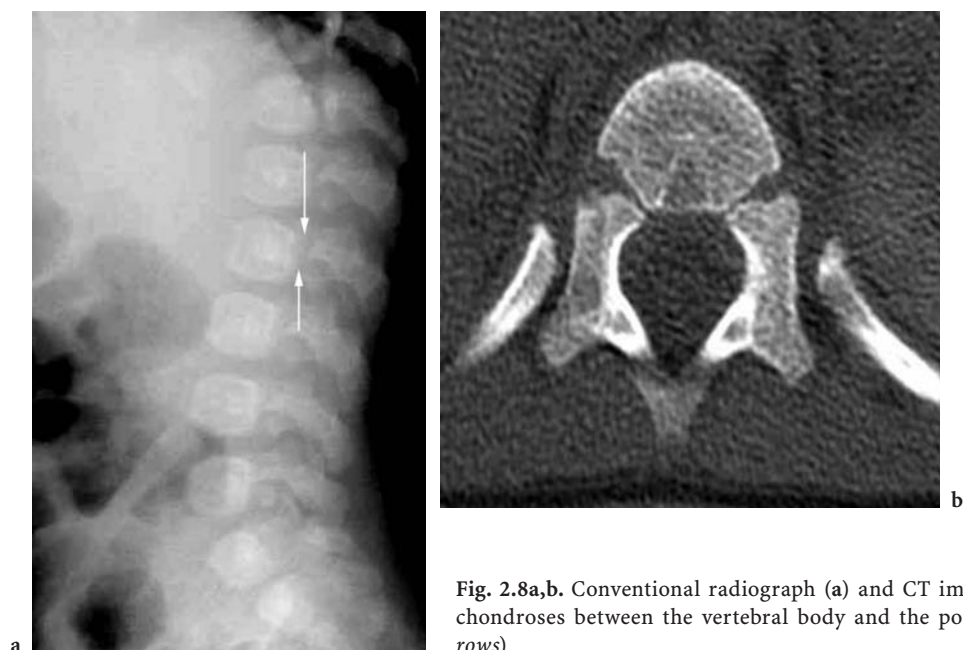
Conventional radiograph (a) and CT image (b) demonstrate synchondroses between the vertebral body and the posterior neural arches (arrows)
